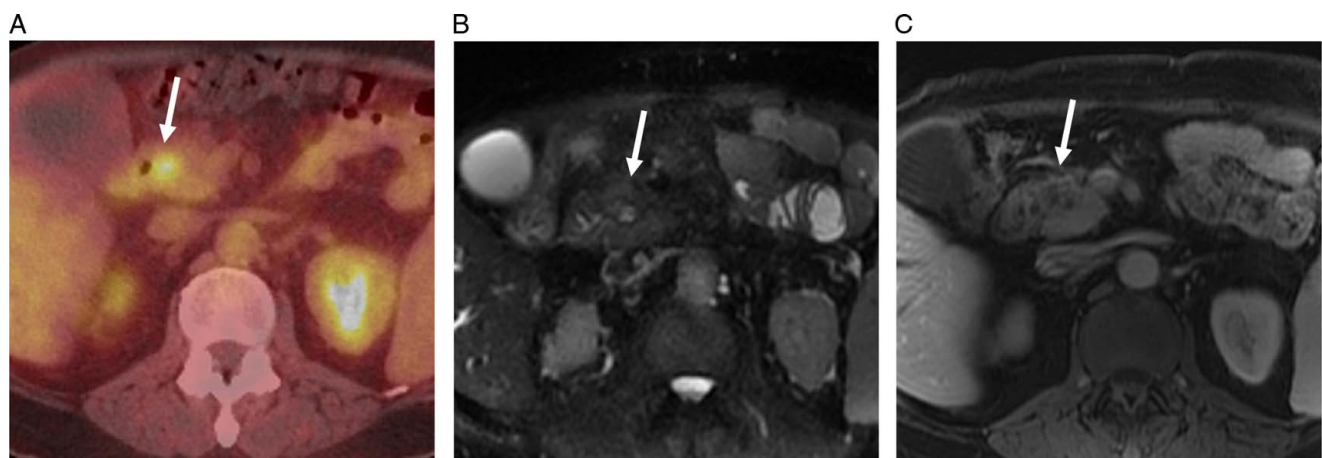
A 76-year-old man with a history of chronic lymphocytic leukemia who underwent positron emission tomography/computed tomography (PET/CT) for treatment surveillance. Axial-fused PET/CT (A) image showed an FDG (fluorodeoxyglucose) avid focus in the pancreatic head (arrow). Axial T2-weighted MR (magnetic resonance) image (B) showed a mildly T2 hyperintense mass in the pancreatic head (arrow). Axial intravenous (i.v.) contrast-enhanced T1-weighted MR image (C) showed heterogeneous enhancement within the pancreatic head mass (arrow). Biopsy confirmed diagnosis of PDAC (pancreatic ductal adenocarcinoma).
